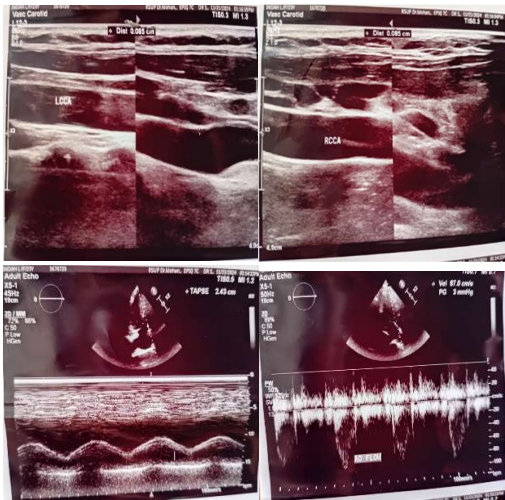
Echocardiography Examination
